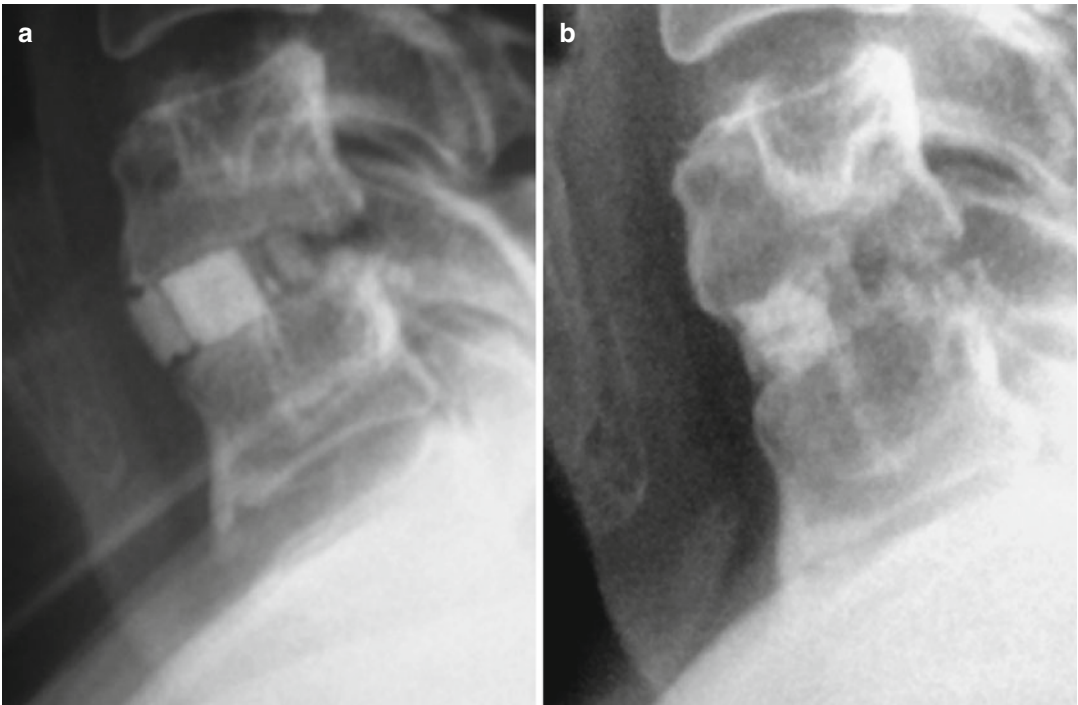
Fusion and resorption of the Duocage®: extension X-rays at (a) 4 months and (b) 32 months after surgery without plate
